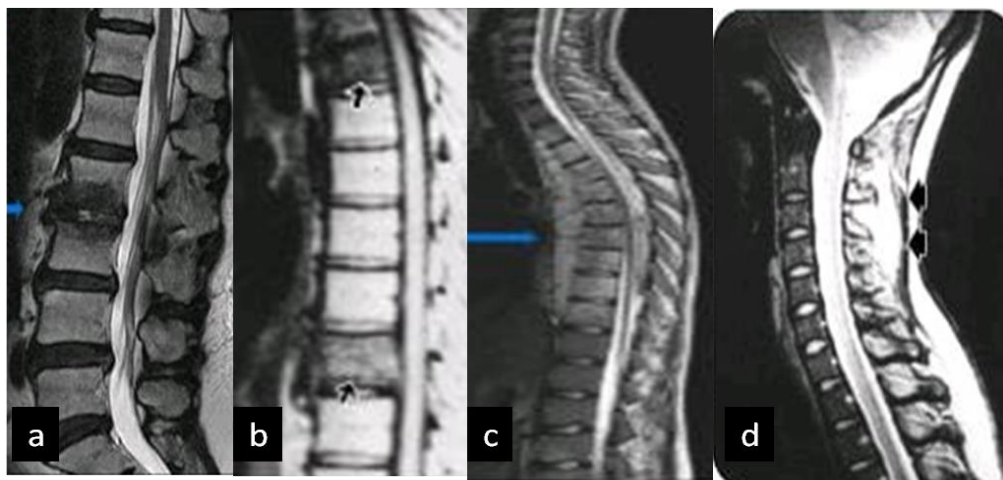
Magnetic resonance imaging – T2 weighted – showing various types of spinal tuberculosis (blue and black arrows): (a) paradiscal (b) central (c) anterior (d) appendicular spondylodiscitis. Images derived from www.slideshare.net
